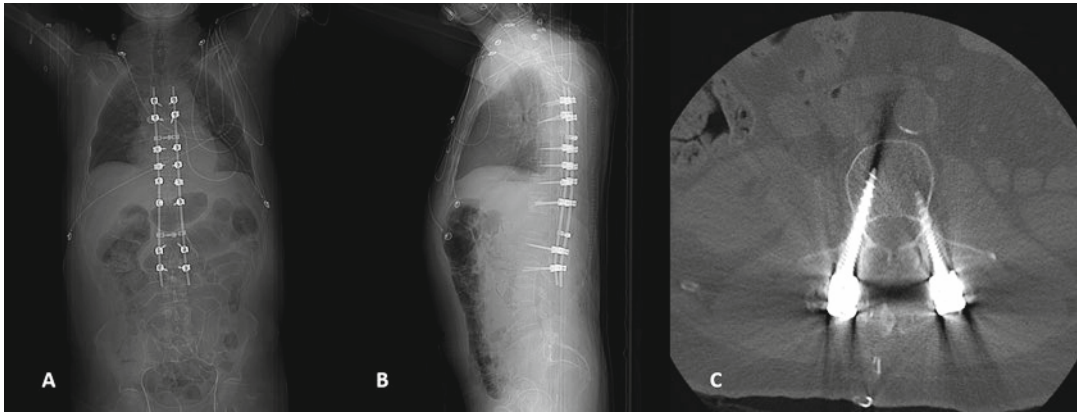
Postoperative films. (a) AP standing X-ray. (b) Lateral standing X-ray. (c) Axial CT
